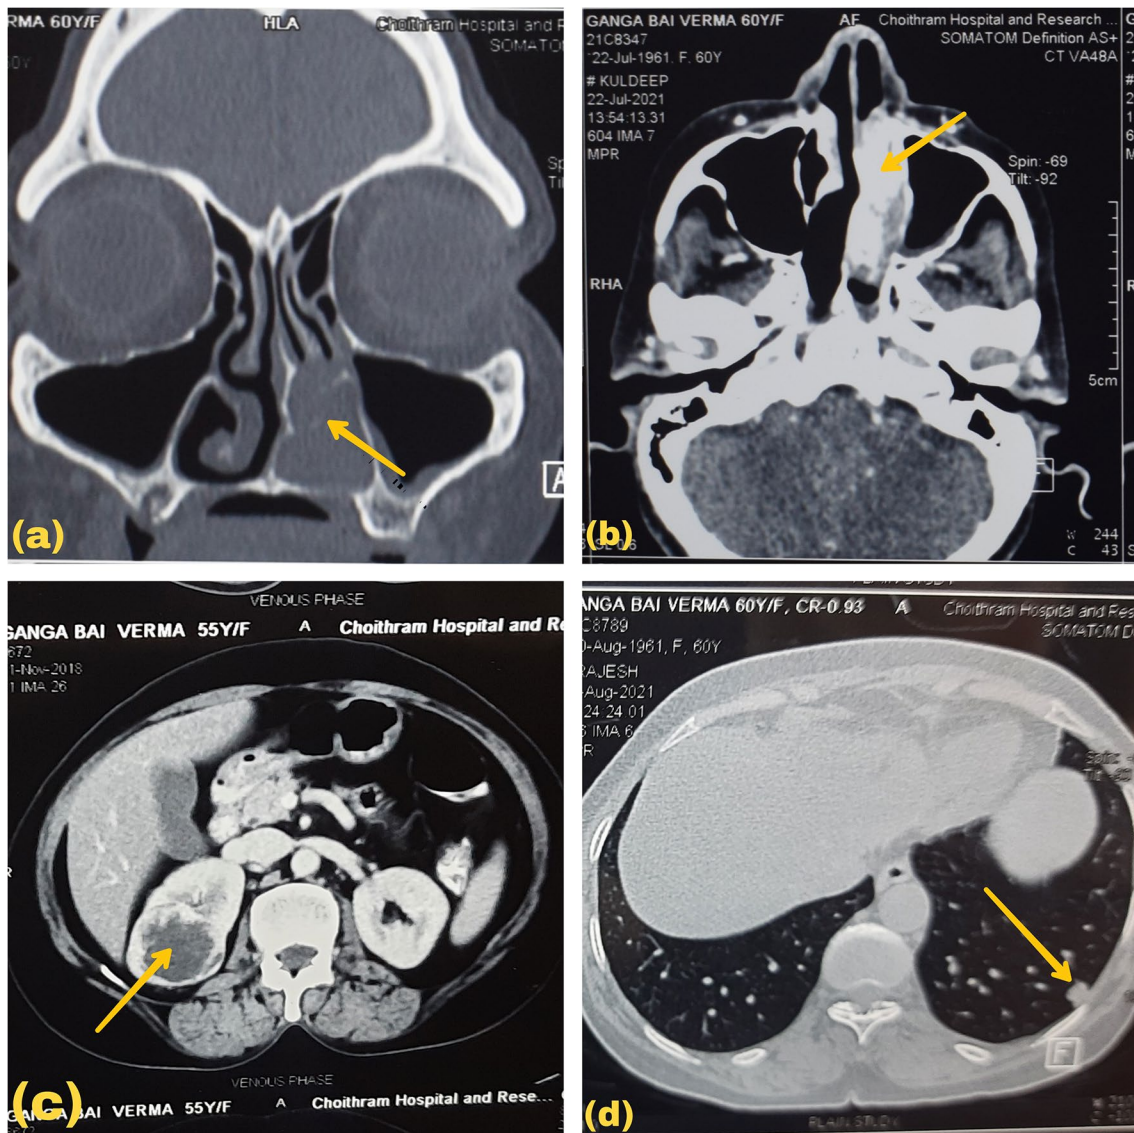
a CT PNS with spur left & left nasal mass. b CECT PNS with enhancing mass. c CT Abdomen with right RCC renal mass. d CECT Chest with subpleural metastatic lesion in left lung
